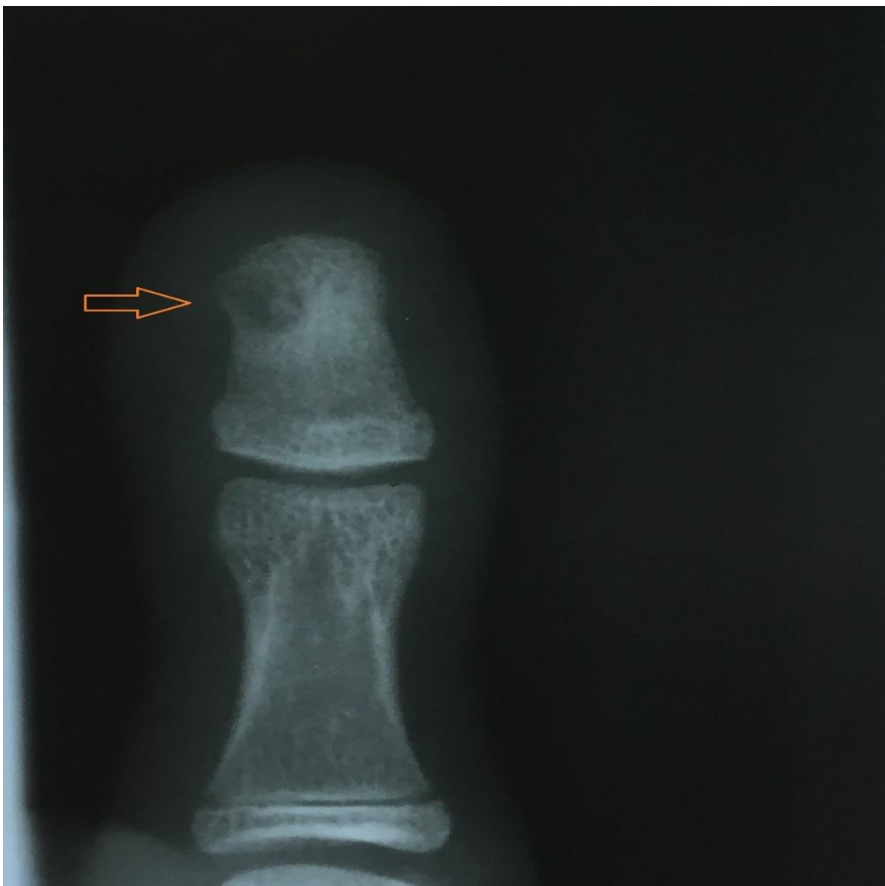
Anterior posterior view radiography of thumb indicating lucent lesion with sclerotic margins.
